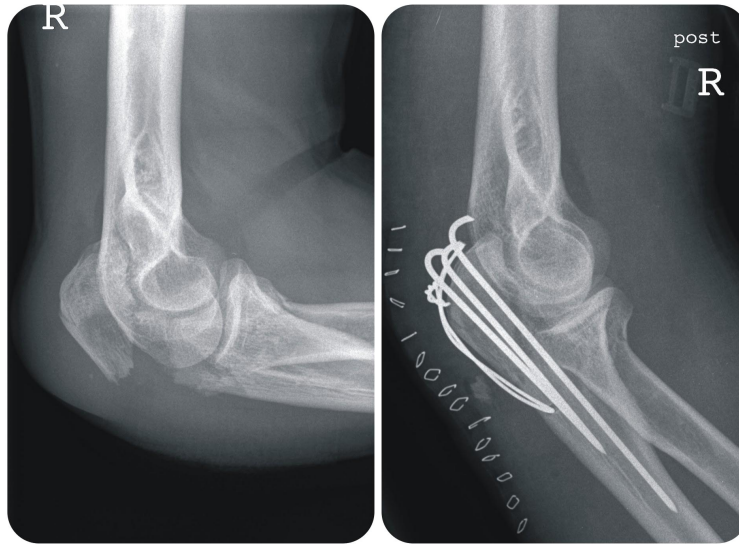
The upper part of the ulna, just above the elbow joint, is broken, as you can see in the X-ray at left. The x-ray at right was taken after a surgeon inserted a system of pins and wires across the fracture to bring the two pieces of the ulna into close proximity.
